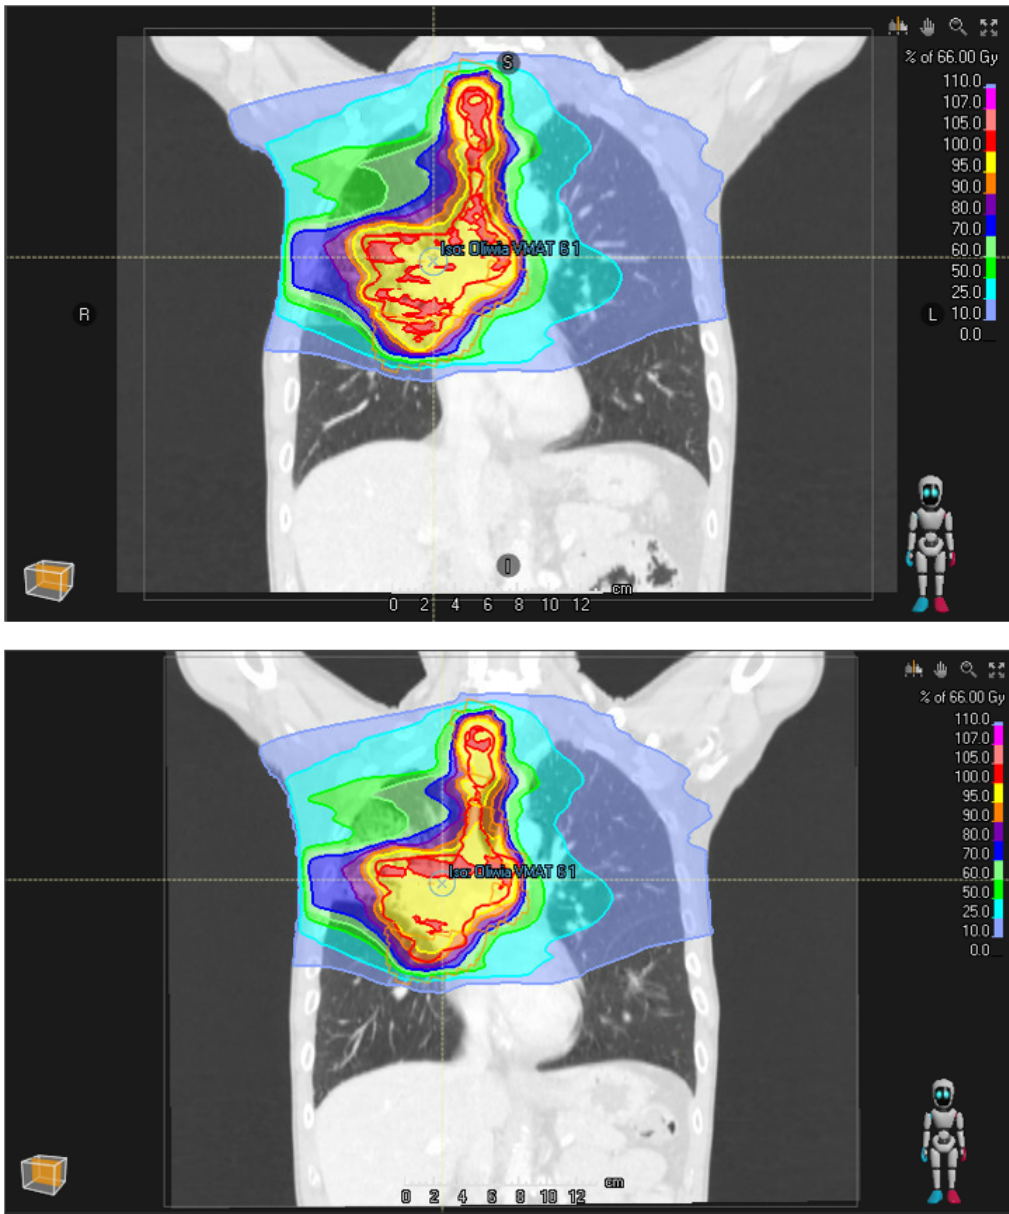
Dose distribution using VMAT technique for patient 6, based on the planning CT (above) and recalculated on the control CT (below). The red solid line shows the ICTVu.
